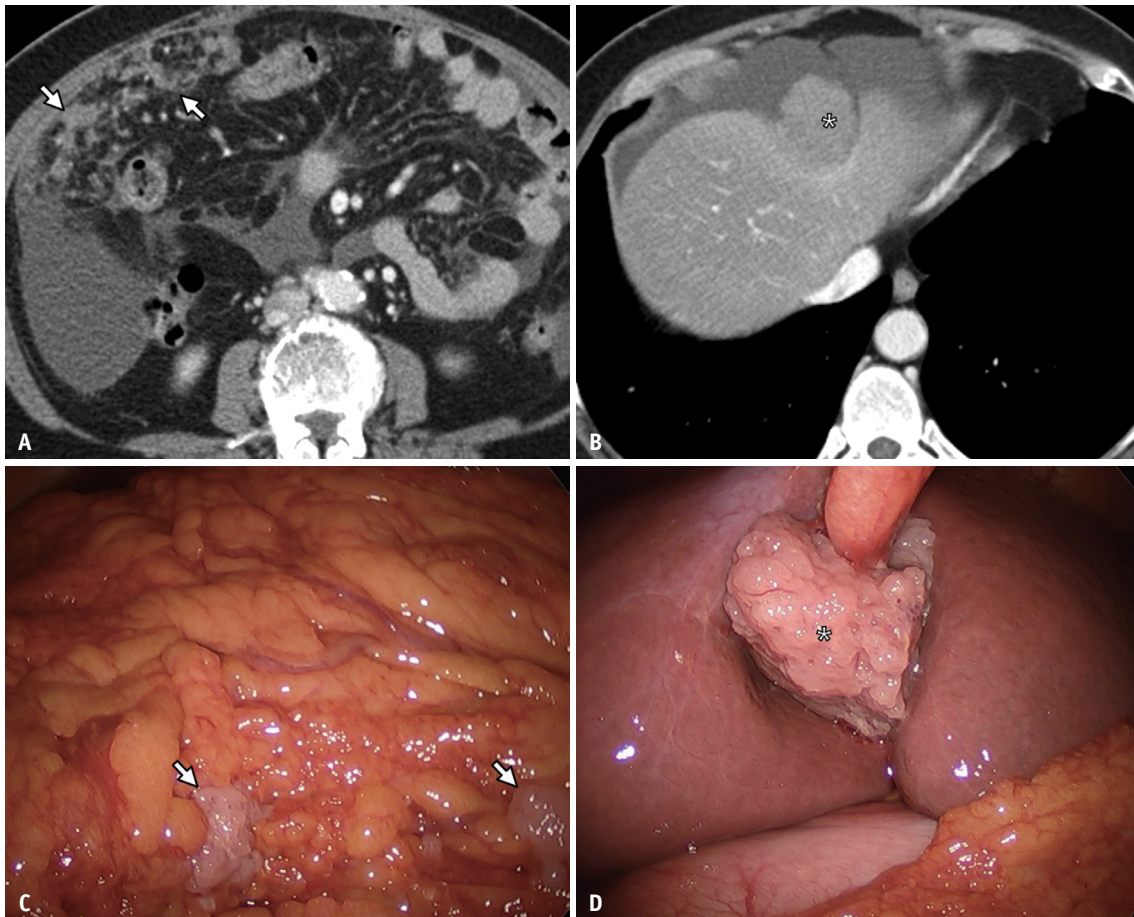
56-year-old female with stage IV ovarian cancer. A, B. Axial contrast-enhanced portal phase CT scans show seeding nodules on the omentum, mesentery (arrows), and liver surface near the falciform ligament (asterisk). C, D. In laparoscopy, there were corresponding lesions; omental disease (arrows), and superficial liver metastasis (asterisk). The predictive index value is 8 (superficial liver metastasis, stomach infiltration, peritoneal carcinomatosis, and diaphragmatic disease).
